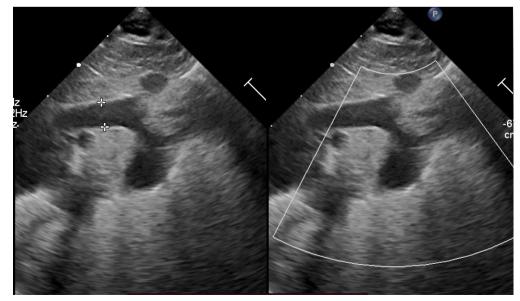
Postnatal ultrasound of a neonate with measurement of an atypical vessel
